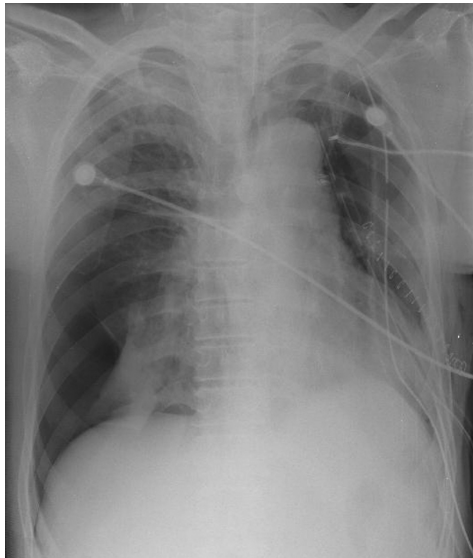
Postoperative chest radiograph shows pneumothorax at the right lung and a deviated trachea on the left side.
